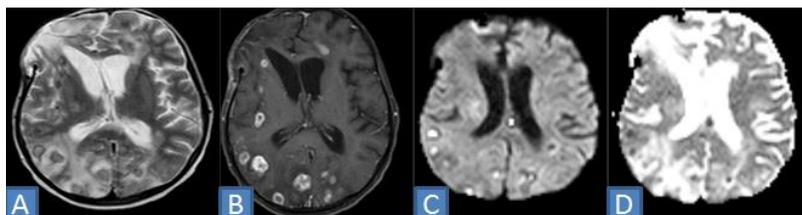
A proven case of fungal granulomas, multiple supra and infra tentorial lesions were seen in bilateral fronto-parieto-occipital region. These showed hyperintense core with hypointense rim on T2W images (A) with significant edema. Post contrast images showed peripheral rim enhancement (B).DWI Images (C) showed diffusion restriction with low ADC values (D).
